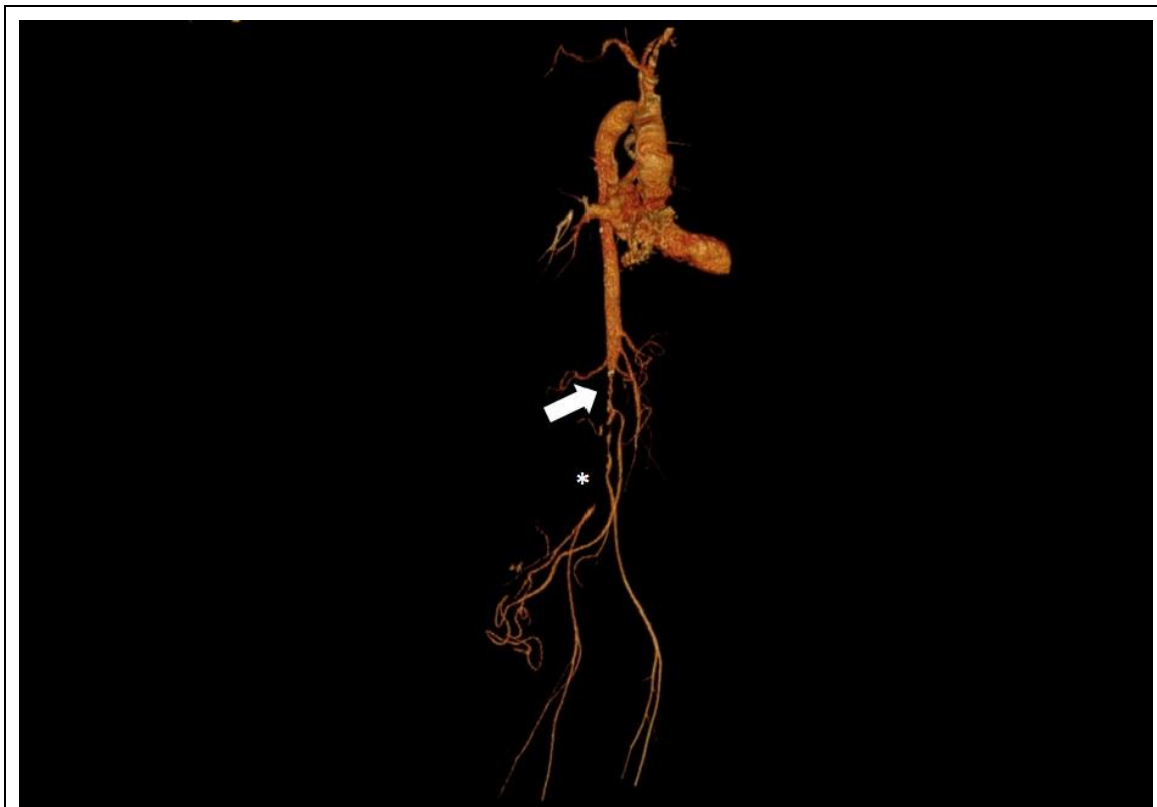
Abdominal computed tomography with contrast revealing diffuse narrowing of infrarenal aortic (arrow) and occlusion of the right common iliac artery (*) with distal repermeabilization.
